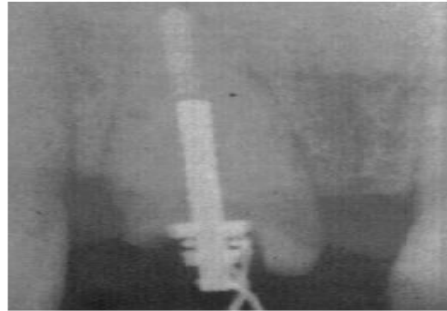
Radiograph demonstrating post placement 6mm within alveolar bone prior to eruption
